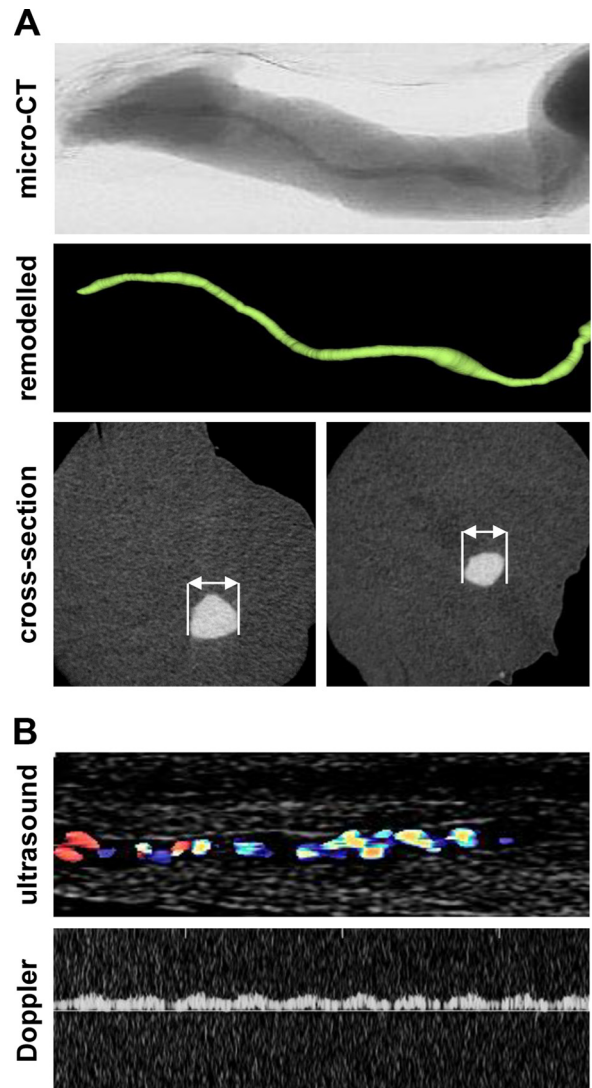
Microcomputed tomography and Doppler ultrasound analysis of umbilical cord veins. (A) Umbilical cord veins were perfused with MicroFil contrast solution, recorded by microcomputed tomography, and digitally processed; total length analyzed, 1.8 cm; diameter, 1.3 (left) or 0.9 (right) mm. (B) For ultrasound analysis, umbilical cord veins were washed and infected with barium sulfate (10%, resuspended in PBS).
